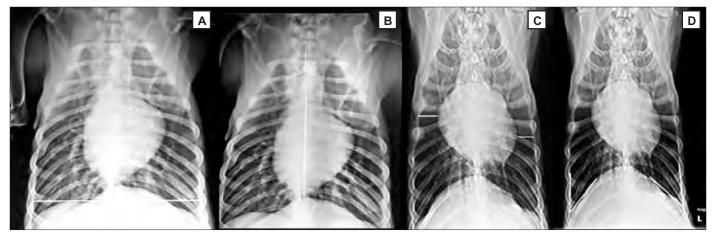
Ventro-dorsal (VD) radiographic views - (A) Measurement of thoracic width (TW) from the distance between the medial borders of the eight ribs at their most lateral curvature. (B) Measurement of Thoracic cavity length (TL) from the distance between the thoracic inlet and the most cranial portion of the cupula of the diaphragm. (C) measurement of the distance between the right and left thoracic wall in relation to the cardiac silhouette. (D) Measurement of costophrenic angles from the right and left sides.
